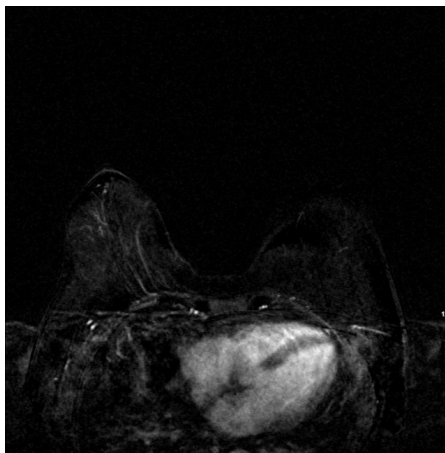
Breast MRI – no lesion found.
